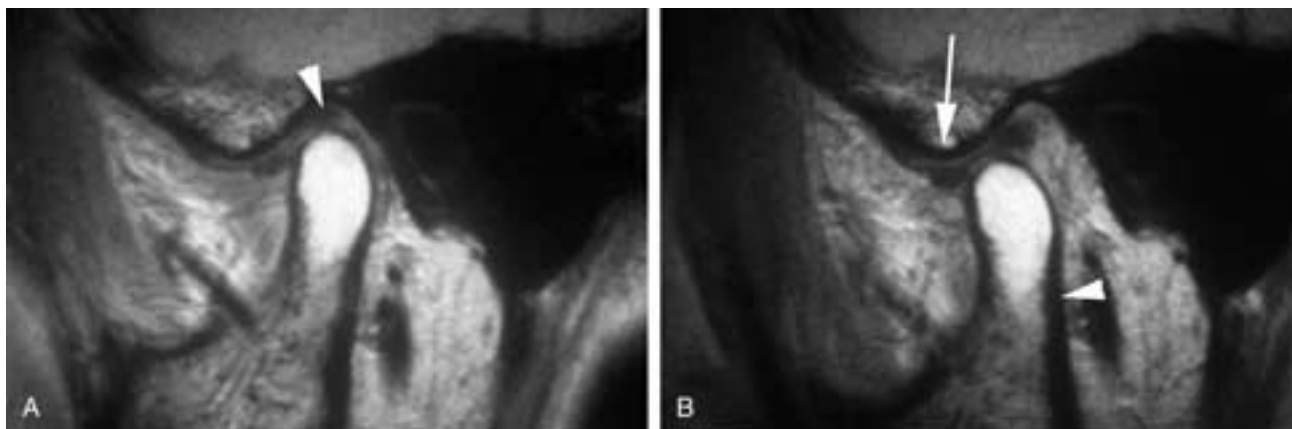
Normal MR imaging, Normal TMJ. A, The posterior thick band (*arrowhead*) is located immediately superior to the condylar head. Just anterior to this band is the central thin region. The low signal just anterior to the condylar head is the anterior thick band. The disk gives a “bowtie” appearance due to the anterior and posterior thick bands. B, Open-mouth position. The mouth is slightly open. The disk has translated down anteriorly so that the anterior thick band of the disk is immediately inferior to the articular eminence (*arrow*). The condylar head has rotated with respect to the disk. Note how the posterior edge of the mandible has rotated posteriorly (*arrowhead*) compared to A.
